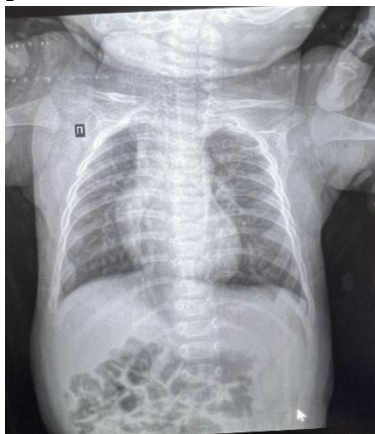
In Patient No. 3, chest radiography performed on days 3–4 of illness demonstrated radiological findings consistent with bilateral bronchopneumonia.
